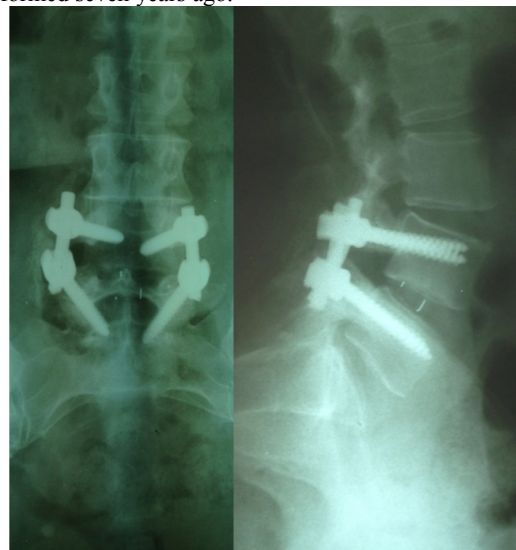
Postoperative radiographs of the patient shown in Fig 1. Note that instrumented TLIF restored both intervertebral height and lumbar lordosis.
